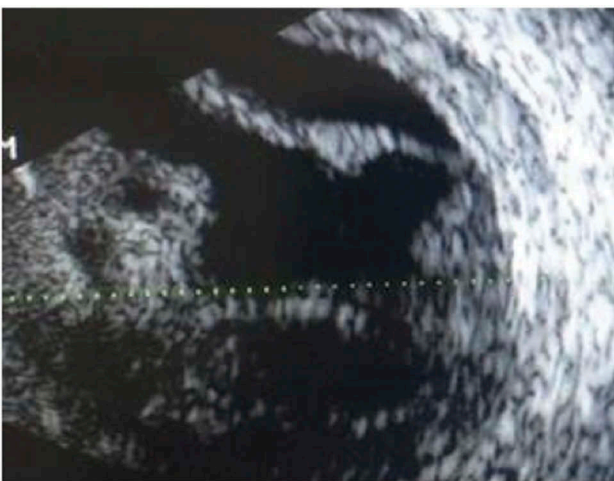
B-scan ultrasonography of the left eye demonstrating choroidal effusions, loculated vitreous debris, and vitreal membranes on the initial day of presentation.
